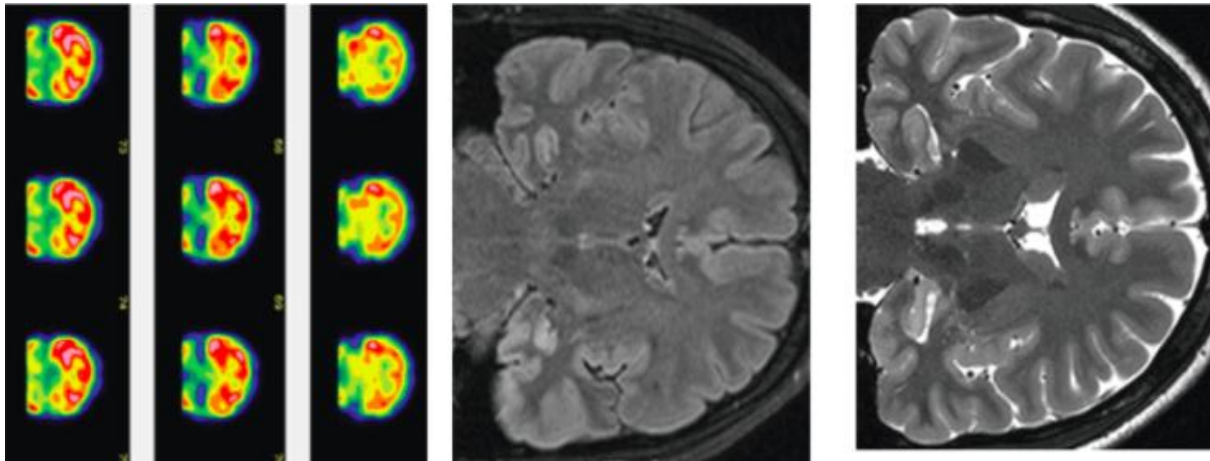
Mesial Temporal Sclerosis in MRI and PET Studies: The image on the Right is a coronal T2-weighted MRI exhibiting a smaller and slightly bright left hippocampus
